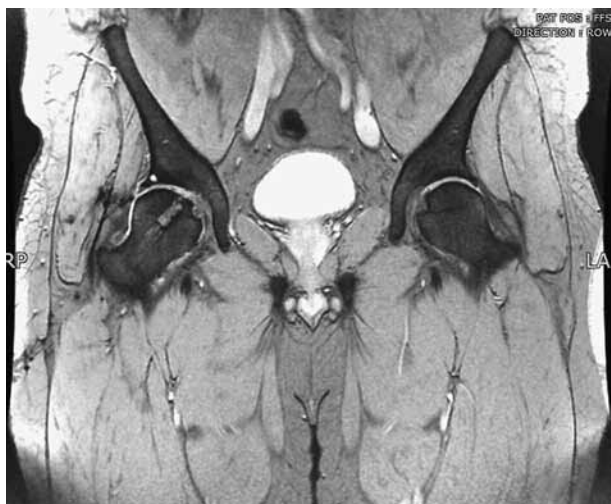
Post-operative MRI at 6 months, coronal view. The Trufit ® Plug is visible *in situ*.
